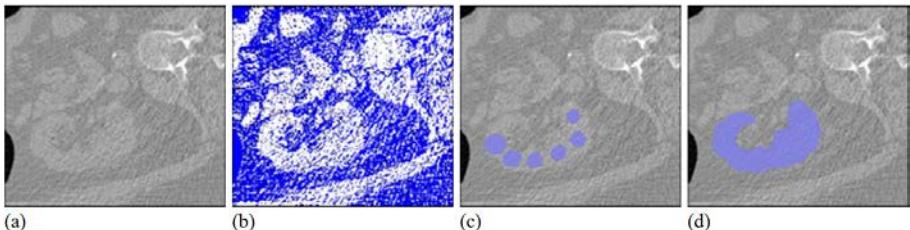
An example of kidney segmentation in a low contrast CT volume. (a) An axial slice from the CT volume. (b) A map of $P(\mathbf{x} \in \text{Object}) - P(\mathbf{x} \in \text{Background})$, computed using tissue classification. White pixels have high object probability; blue points have high background probability. Note that simple thresholding of this map will lead to a very noisy segmentation. (c) Initialization of the active contour method using five spherical seeds. (d) Segmentation after 1000 iterations of evolution. Note that the contours have merged to form a single surface.
